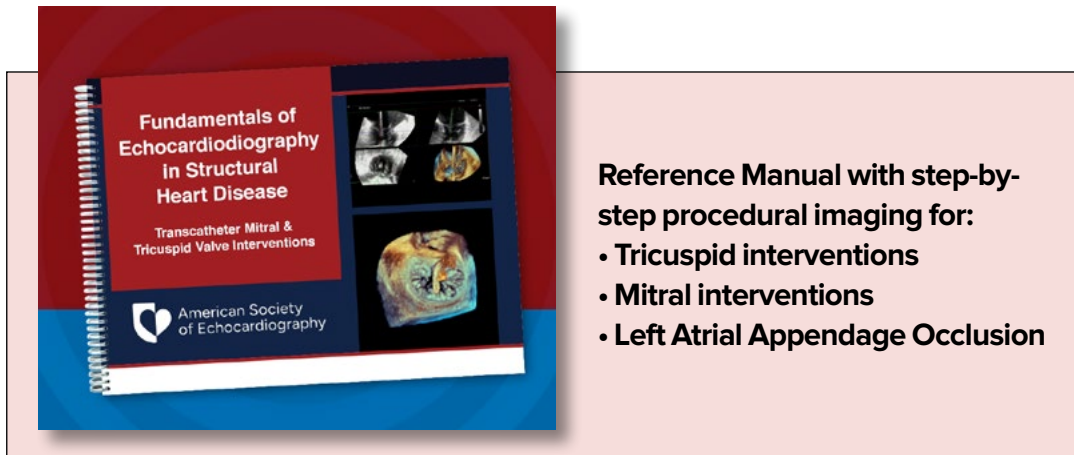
Fundamentals of Echocardiography in Structural Heart Disease Book
